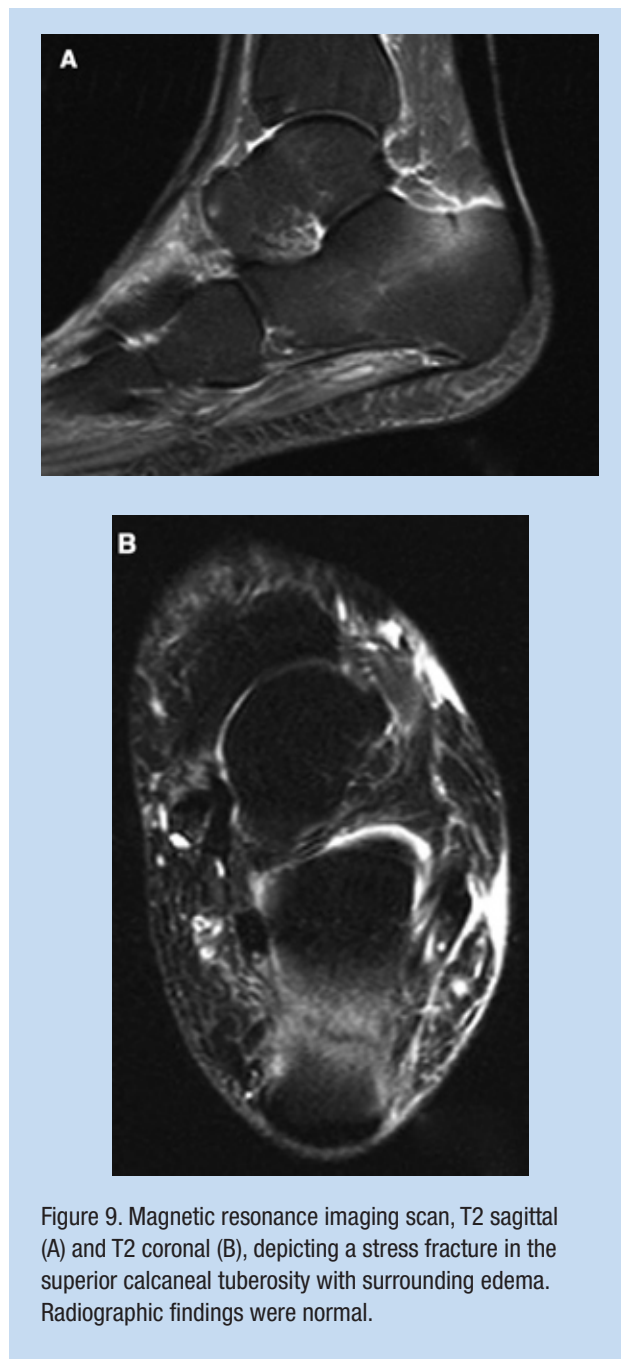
Magnetic resonance imaging scan, T2 sagittal (A) and T2 coronal (B), depicting a stress fracture in the superior calcaneal tuberosity with surrounding edema. Radiographic findings were normal.
